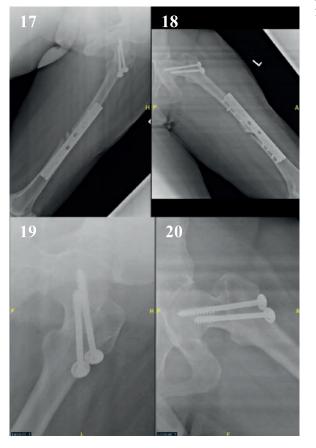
Plain radiographs of the patient at two months post-operatively. No sclerosis of head of femur seen and the neck of femur fracture was not displaced.
